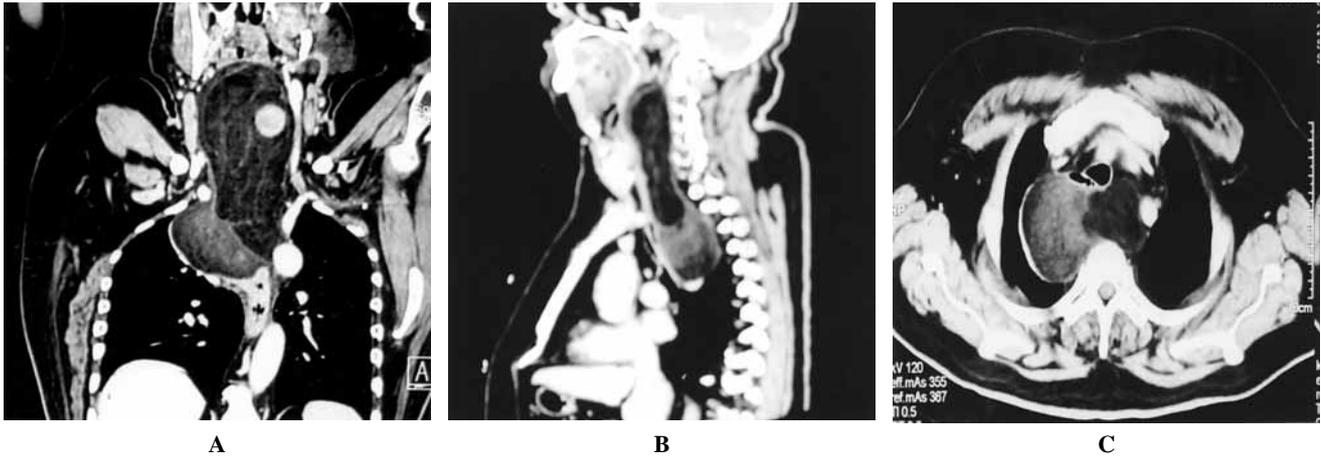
CT scans (coronal (A), lateral (B), and cross sectional (C) views respectively) showing the mass extending from C2 vertebral level in the neck to the level of carina in the mediastinum and involving both the hemithoraces.
